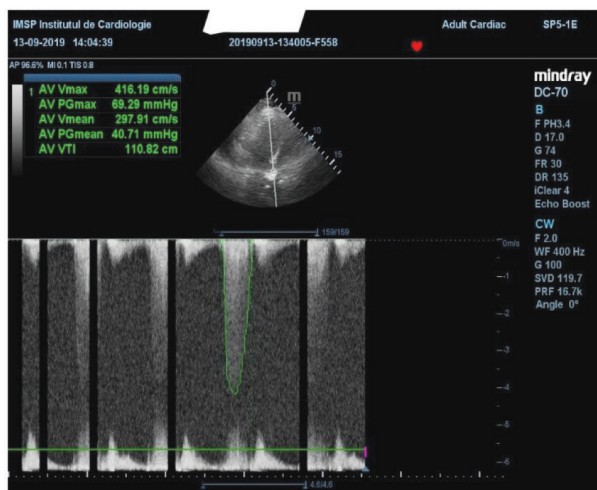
Echocardiography, patient No 3
